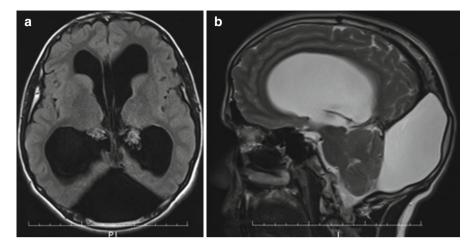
(a, b) MRI scans showed Dandy-Walker malformation and thin corpus callosum
